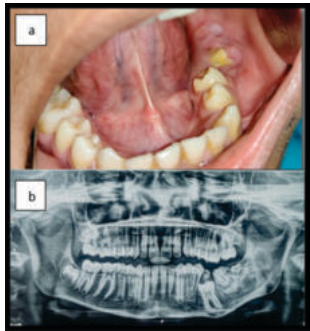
Intraoral Photograph and Pre-operative Orthopantomogram
